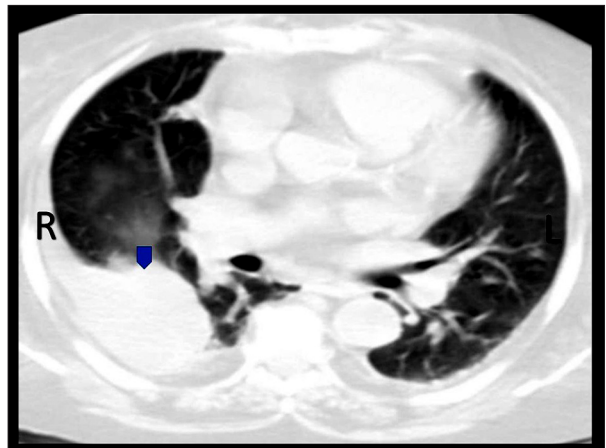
Computed tomography (CT) imaging of the chest in a patient with disseminated nocardiosis. The computed tomography (CT) image of the chest shows a right-sided pleural effusion (arrowhead).
